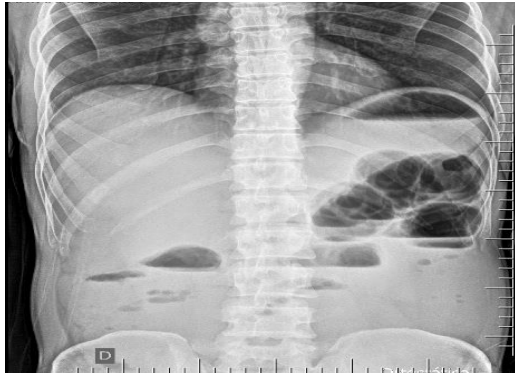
Radiograph of acute obstructive abdomen.
